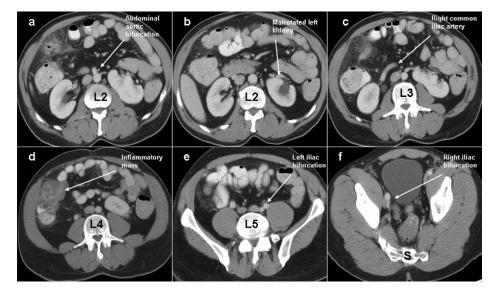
Serial computed tomography scans with intravenous contrast demonstrate various anomalies: (a) high bifurcation of the aorta at L2; (b) malrotated left kidney; (c) right common iliac artery bifurcation at L3; (d) inflammatory mass of the right colon; (e) left iliac artery bifurcation at L5; (f) Right iliac artery bifurcation at the level of the sacrum.
